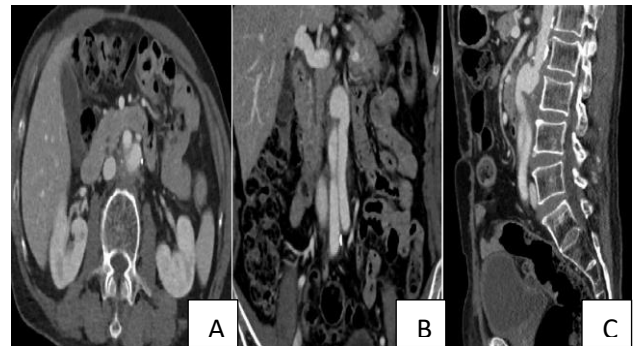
(A-C): Different view on CTA of abdominal aortic graft after 18 months shows appropriate patency of the graft.
